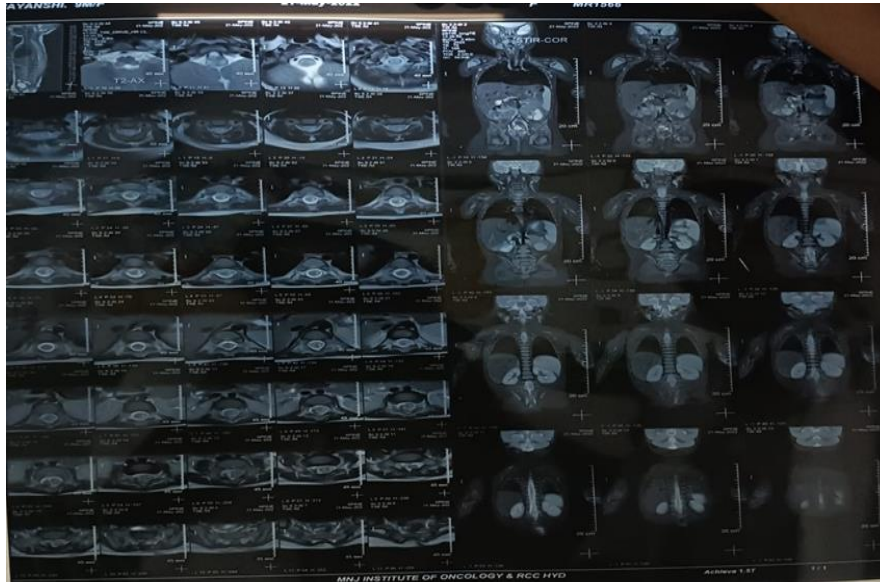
MRI of spine showing Myelomeningitis with organizing abscess in intra and extra medullary region
